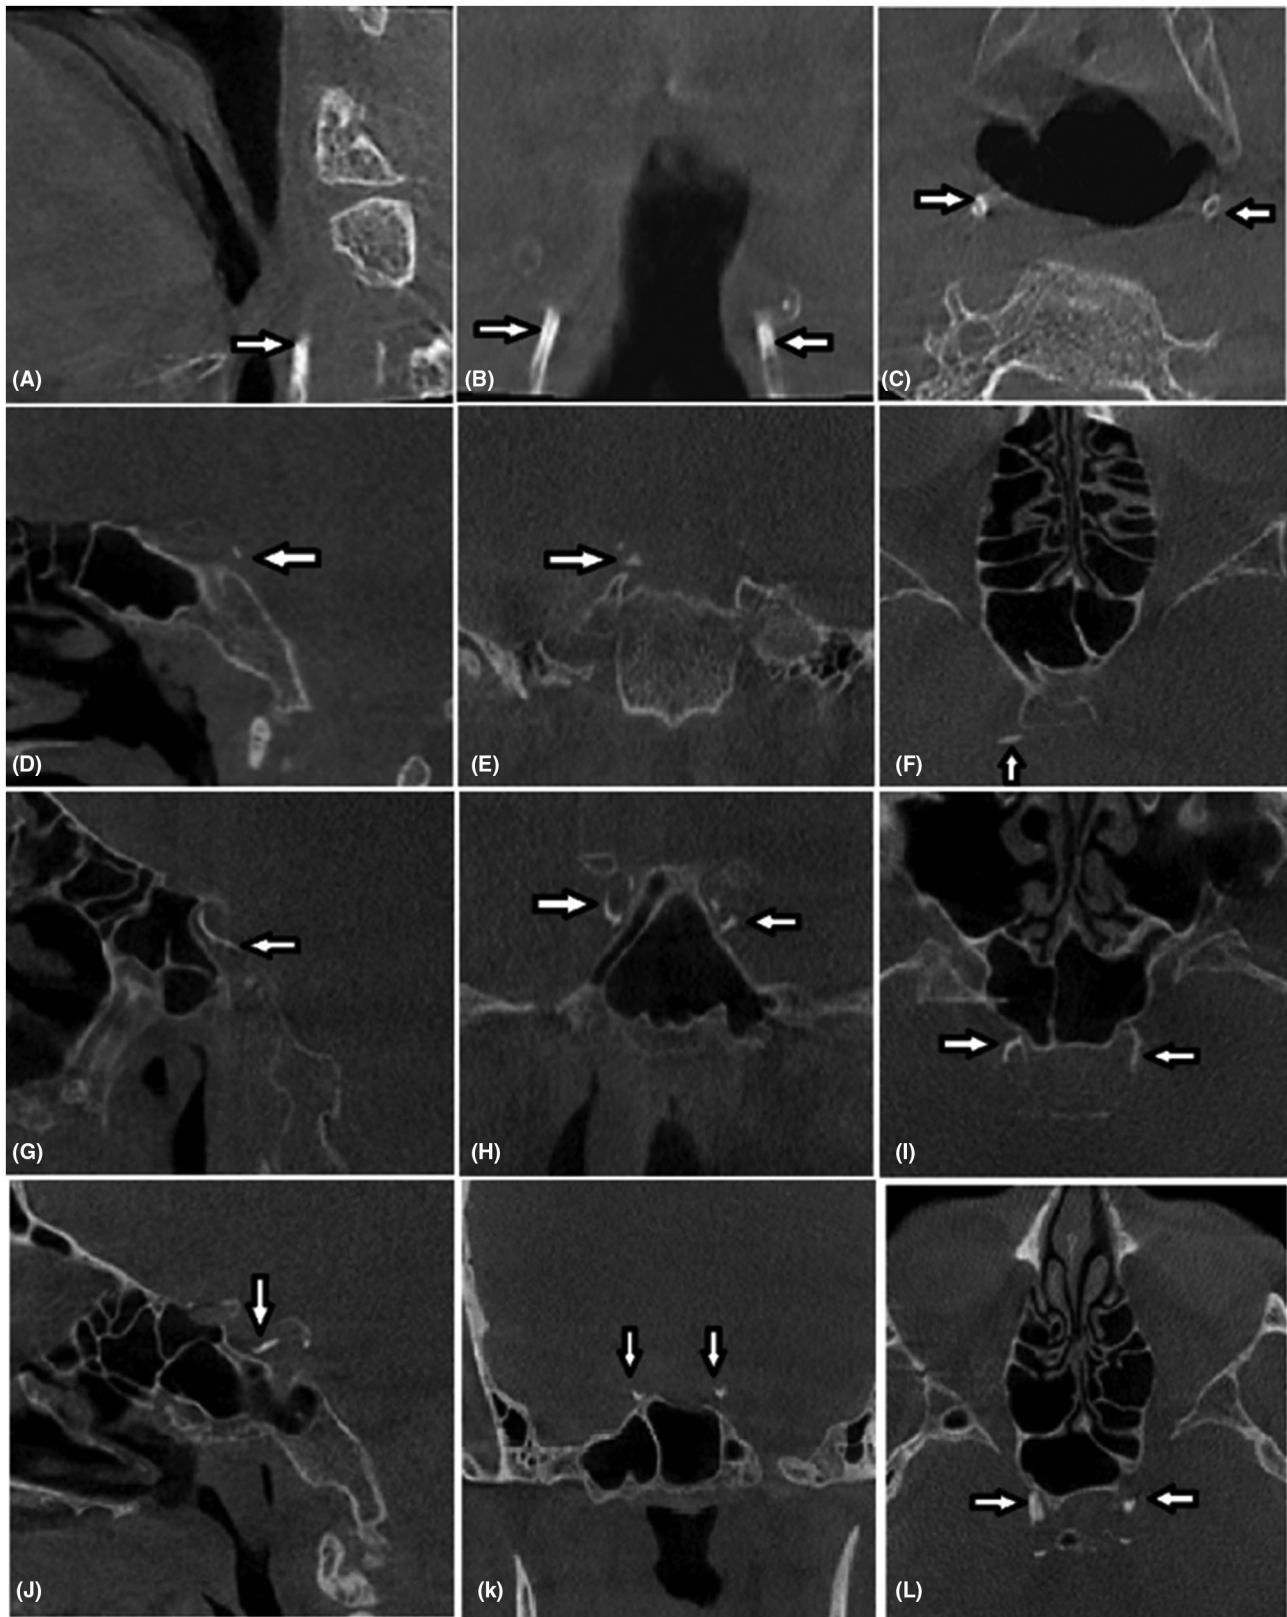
Examples of the different degrees and locations of calcifications on cone beam computed tomography images. (A)–(C) demonstrates calcifications at the cervical segment of internal carotid artery (ICA) in a 66-year-old male. (D)–(F) demonstrates calcifications at the ophthalmic segment of ICA in a 49-year-old male. (G)–(I) demonstrate calcifications at the cavernous segment of ICA in a 66-year-old female. (J)–(L) demonstrate calcifications at the clinoid segment of ICA in a 58-year-old female
